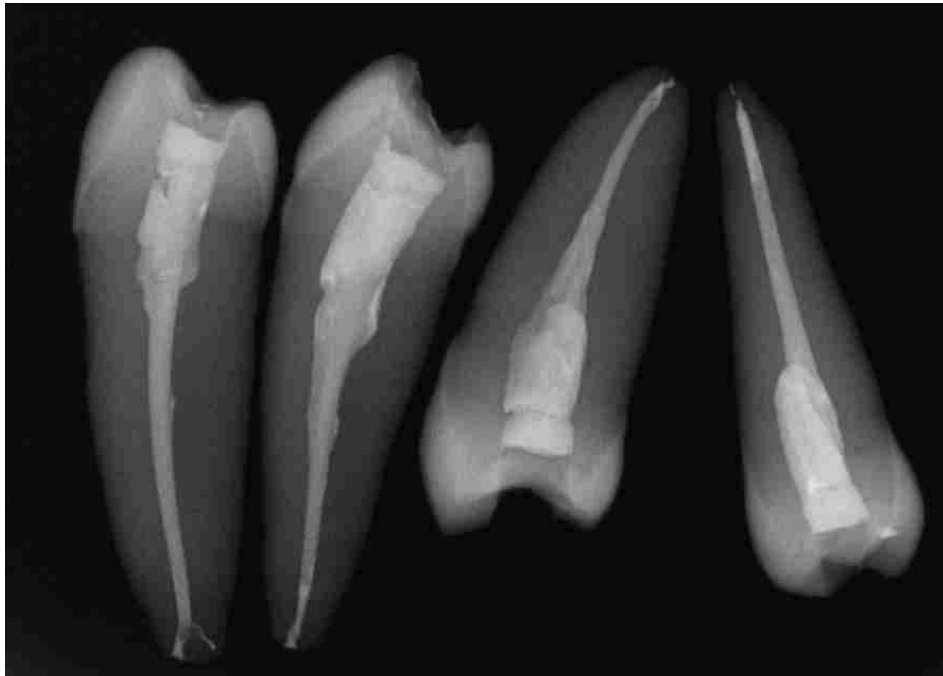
Radiograph of teeth obturated with GuttaCore.
